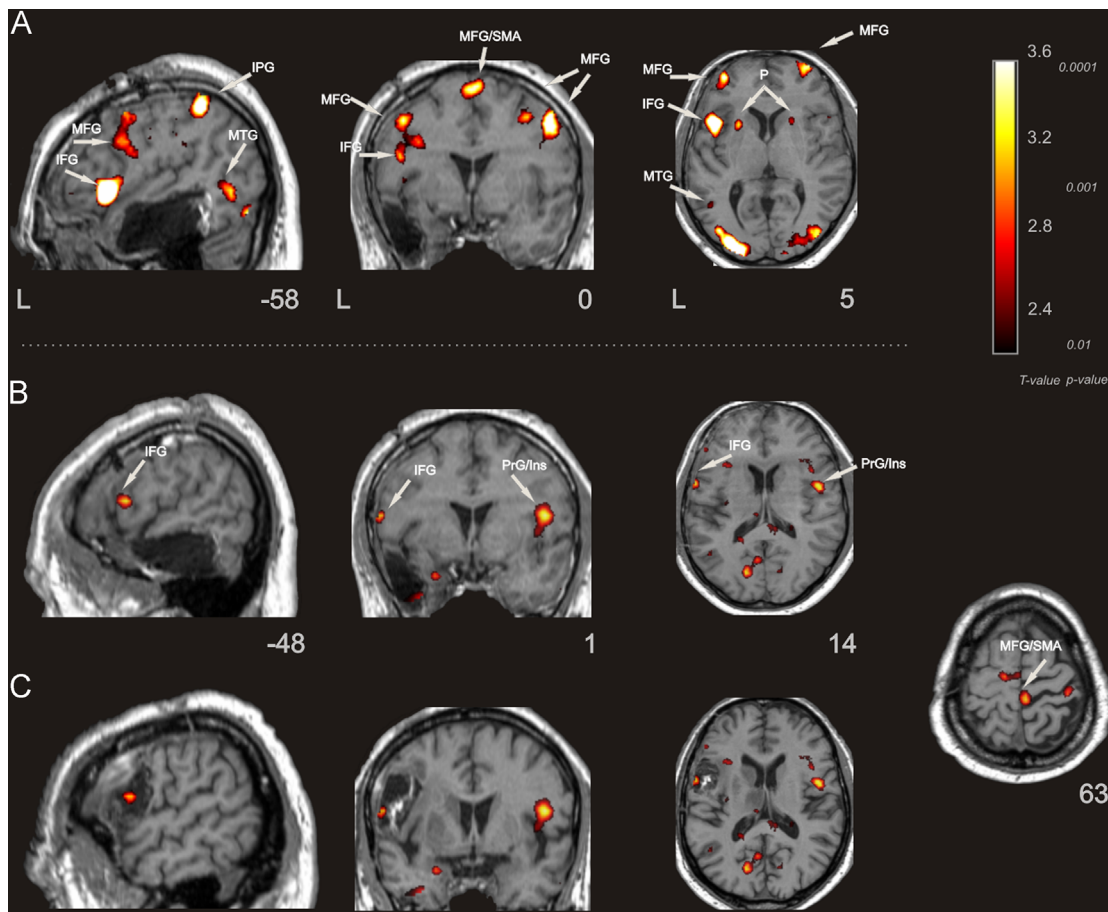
(A) Activation for the single language object naming in both languages (single language-naming condition, L1 & L2 versus rest) in Patient 2 represented on sagittal, coronal and axial views. (B) Activation in the IFG/PrG, PrG/Insula and MFG/SMA during the LS (LS-naming vs. L1 & L2) of Patient 2 superimposed on the post-surgical T1 MRI for the same Patient. (C) Activation during LS (LS-naming vs. L1 & L2) for Patient 2, superimposed on the T1 anatomical image of Patient 1 (showing also the resection carried out in this patient). Notice the overlap between the cortical region resected in Patient 1 and the region activated during the LS task in Patient 2 (images displayed in neurological convention). All structural and functional images shown are normalized with coordinates in the MNI system. (L, left; MFG, middle frontal gyrus; IFG, inferior frontal gyrus; IPG, inferior parietal gyrus; MTG, middle temporal gyrus; SMA, supplementary motor area; PrG, precentral gyrus, Ins, insula).
